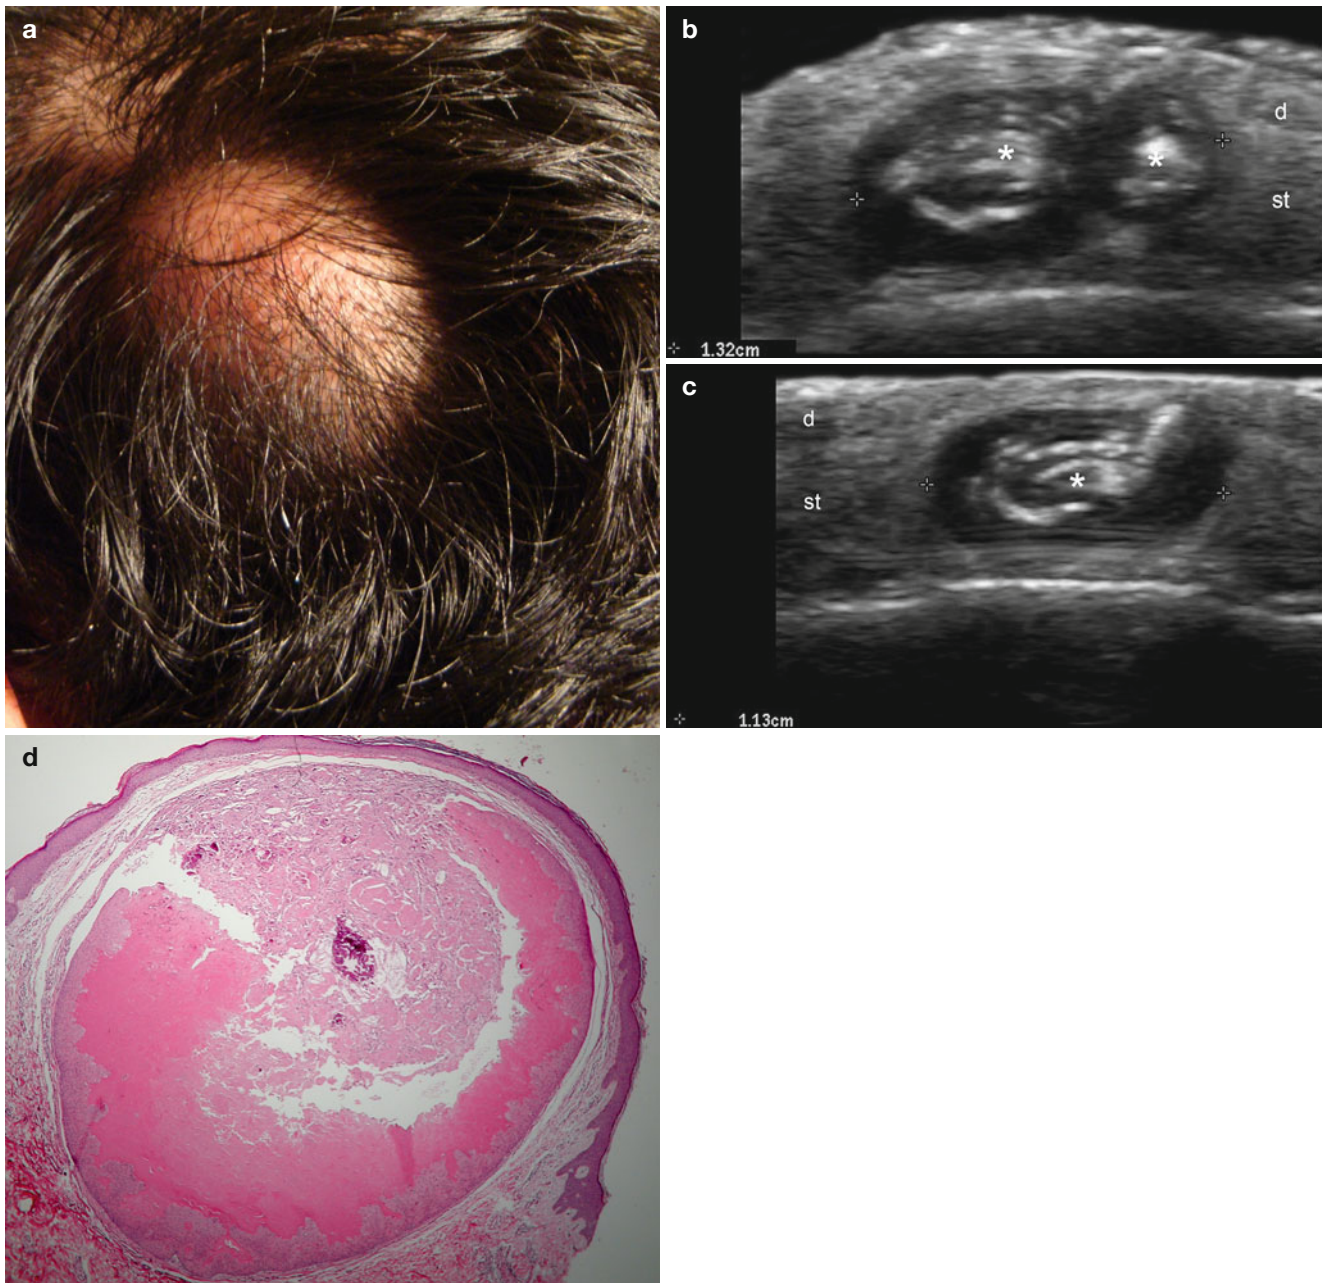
(a–d) Trichilemmal cyst. (a) Clinical image shows focal alopecia and swelling in the scalp. (b) Grey scale ultrasound image (transverse view) demonstrates two adjacent well-defined oval and round-shaped structures (*). These lesions present an hypoechoic rim and hyperechoic center with linear disposition. (c) Grey scale ultrasound image (longitudinal view) of the smallest size cyst demonstrates
